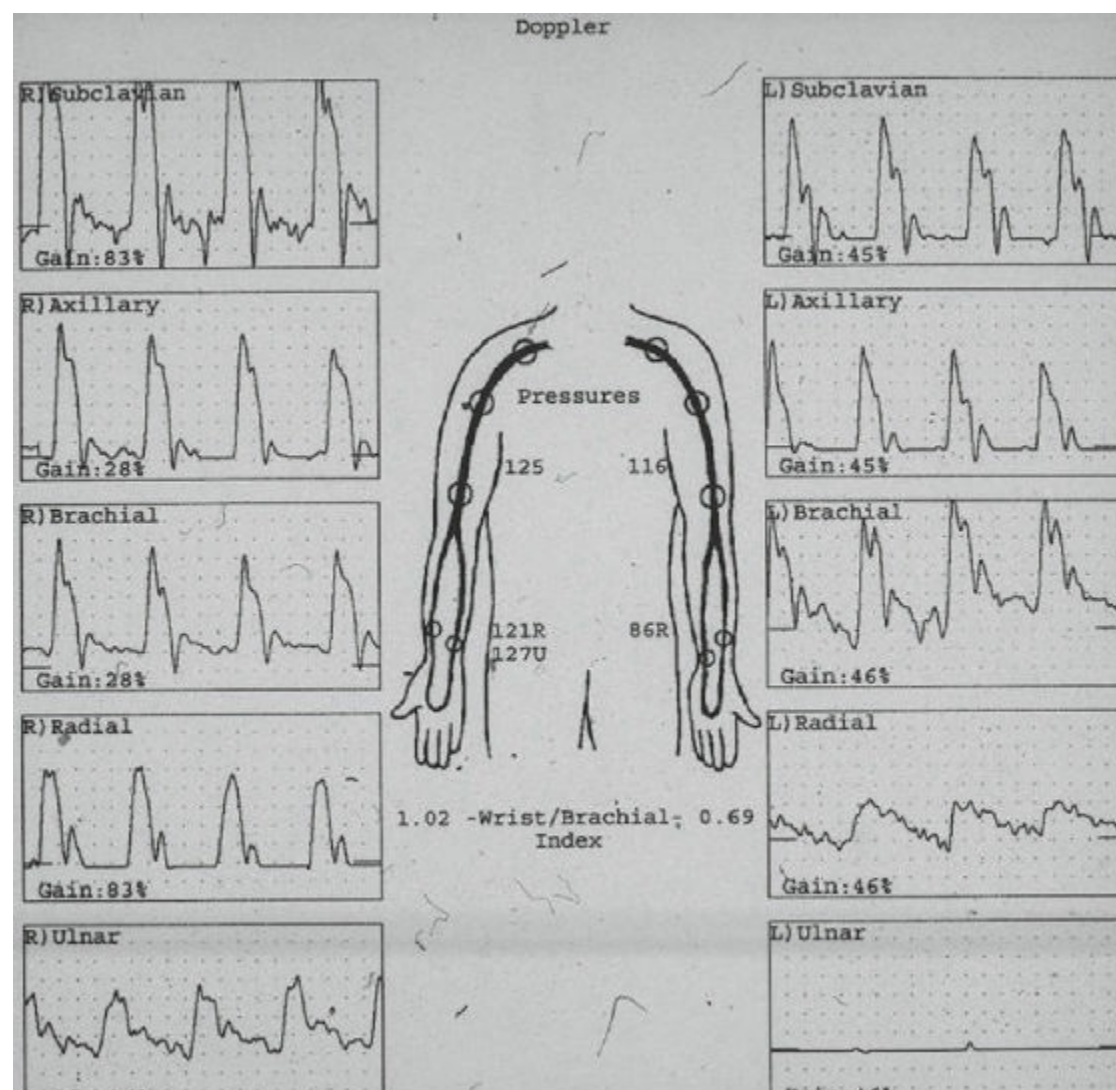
Upper extremity segmental pressures and Doppler waveforms. The findings are normal on the right and suggest radial and ulnar artery or distal brachial artery occlusive disease on the left.
